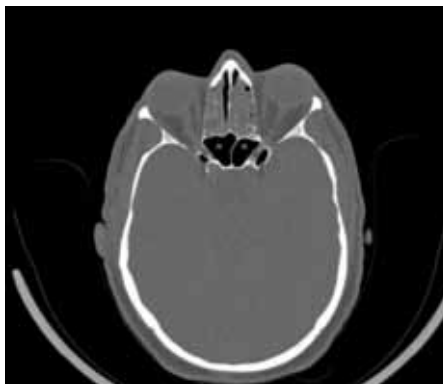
Axial CT image of paranasal sinuses: showing bilateral pneumatization of the anterior clinoid processes (arrows) and bilateral optic nerves (asterisks) inside sphenoid sinus (circles).
